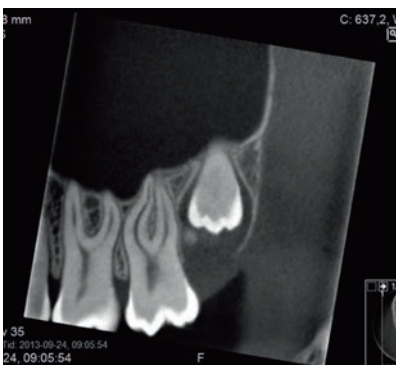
Teeth in left upper jaw imaged by CBCT.
